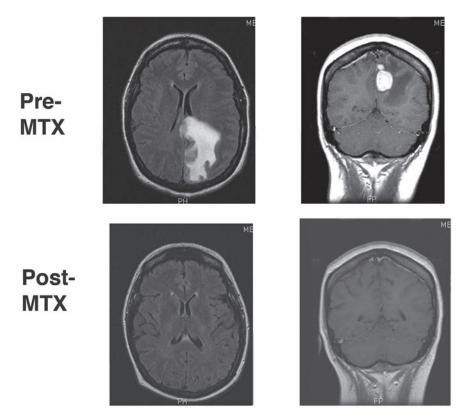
Magnetic resonance imaging of a patient with primary central nervous system (CNS) lymphoma before (above) and after (below) treatment with methotrexate (MTX). After treatment the lymphoma is no longer visible, but the risk for relapse remains high.
